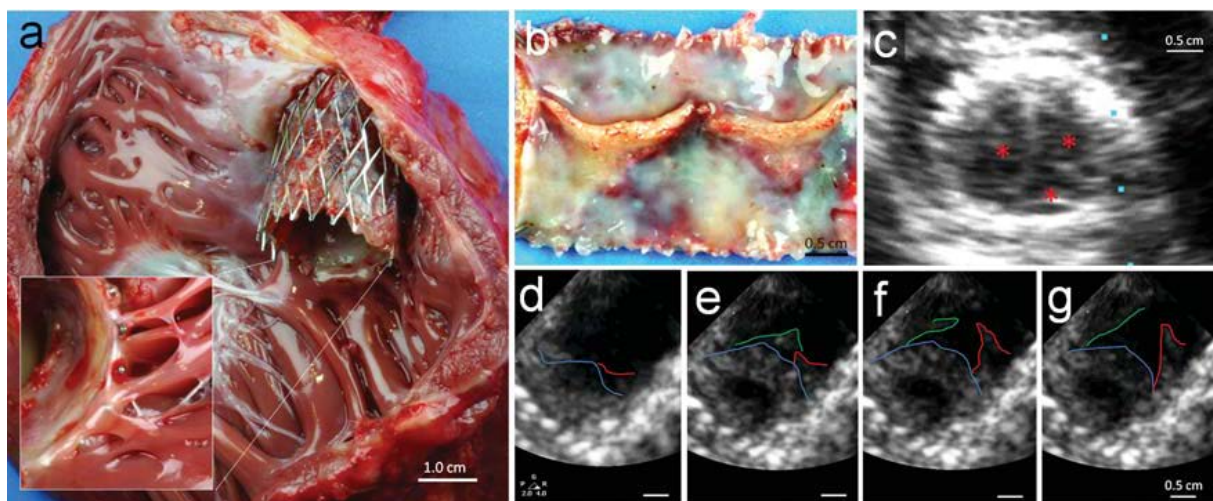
Explant analysis of tissue engineered heart valves. After 4 weeks *in vivo* the stented constructs were well integrated into the adjacent tissue (A). Orthotopical tissue engineered heart valves (B) presented with a cusp-like leaflet structure, with shorter leaflets than native controls. In a final transoesophageal echocardiography-assessment the leaflet co-aptation (C; asterisk indicates leaflets) as well as opening movements of all three leaflets could be visualized (D–G).
